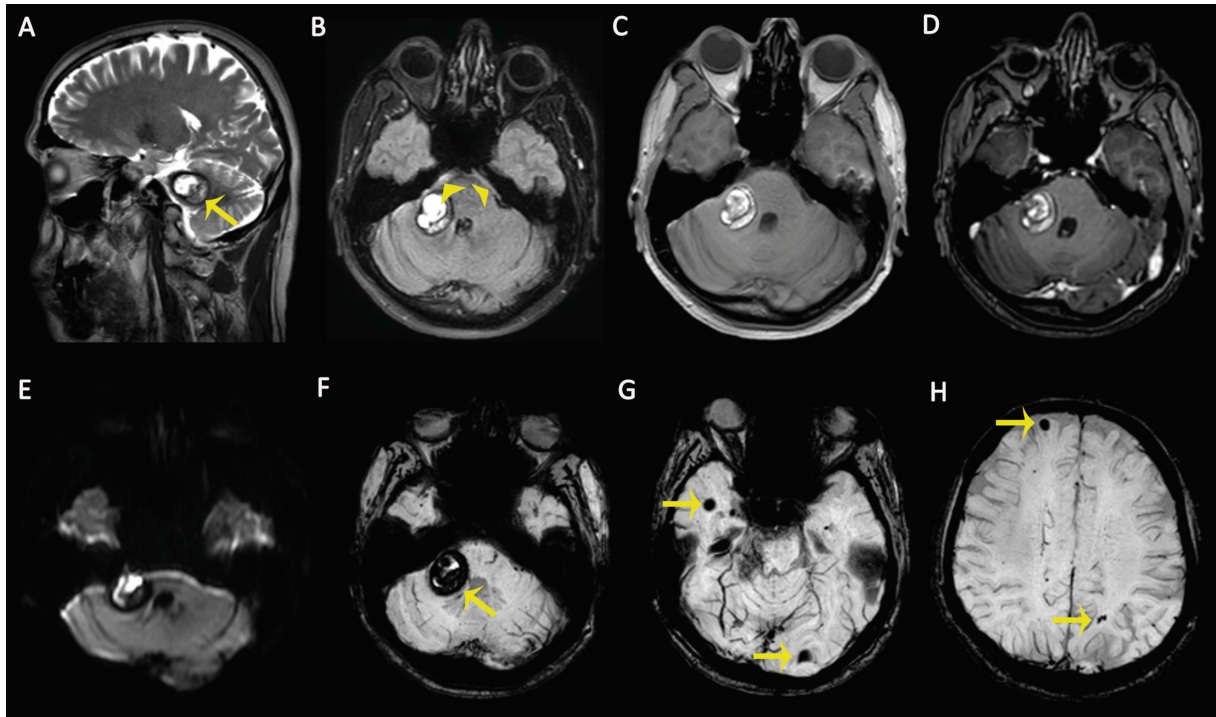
Magnetic resonance (MR) images of a 42-year-old male patient with an acute severe headache. (A) Sagittal T2-weighted image (T2WI) demonstrates a cavernous malformation (CM) in the cerebellopontine angle with peripheral hypointense hemosiderin ring (arrow). (B) Axial fluid-attenuated inversion recovery (FLAIR) sequence demonstrates a CM and perimesencephalic subarachnoid hemorrhage (arrowheads). (C) The lesion is heterogeneously hyperintense on nonenhanced T1-weighted image (T1WI) due to intralesional recent hemorrhage. (D) No enhancement was observed on axial contrast-enhanced T1WI. (E) Recent hemorrhages within the CM cause diffusion restriction on diffusion-weighted imaging (DWI) as hyperintense signals. (F–H) Susceptibility-weighted images (SWIs) show multiple intracranial CMS with “blooming artifacts” (arrows).
